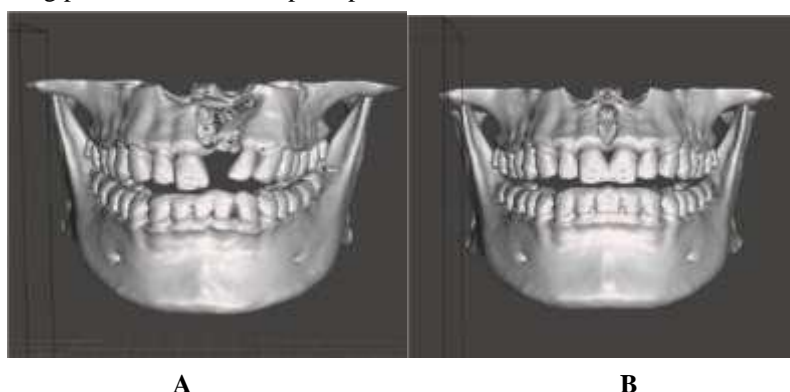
(a) 3D Model of CT Scan and (b) Mirrored 3D Model
